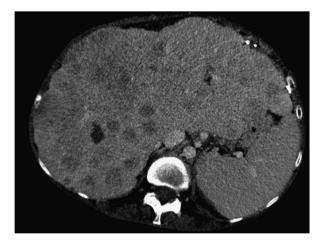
CT imaging of liver metastasis.
